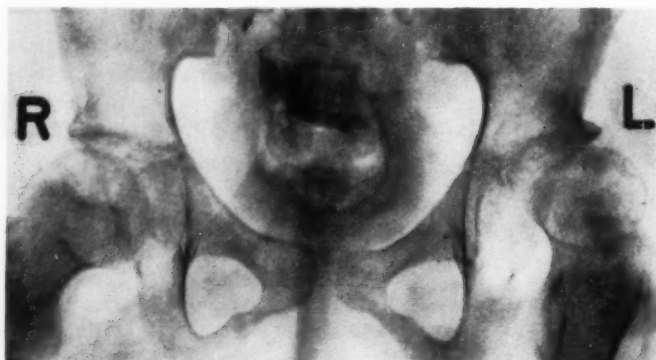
Roentgenogram of hips in Case 1, (3/1/51), two and one-half years after Figure 2. Age 10 1/2 years. Note 1) more marked subluxation of the left hip, 2) an upward angulation of the outer superior acetabular margin, and 3) marked decalcification. Both hips now have a flexion contracture of 25 degrees with little motion in either hip, especially the left.
